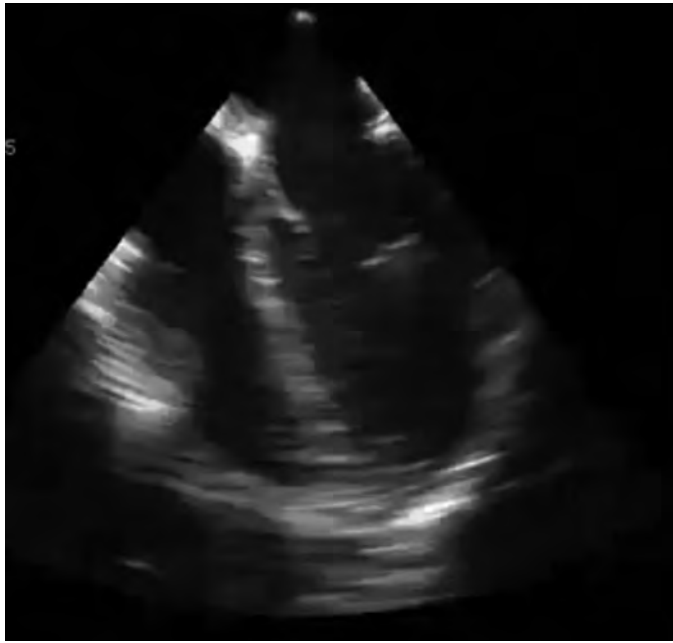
Midesophageal four-chamber view provided by the ClariTEE (Imacor, Inc., Garden City, NY) transesophageal echocardiography probe. The image provides qualitative information (gross function) for hemodynamic management, as well as quantitative data in terms of calculating ejection fraction, but it lacks sufficient Doppler capability. (Courtesy K. Ghadimi, MD.)
